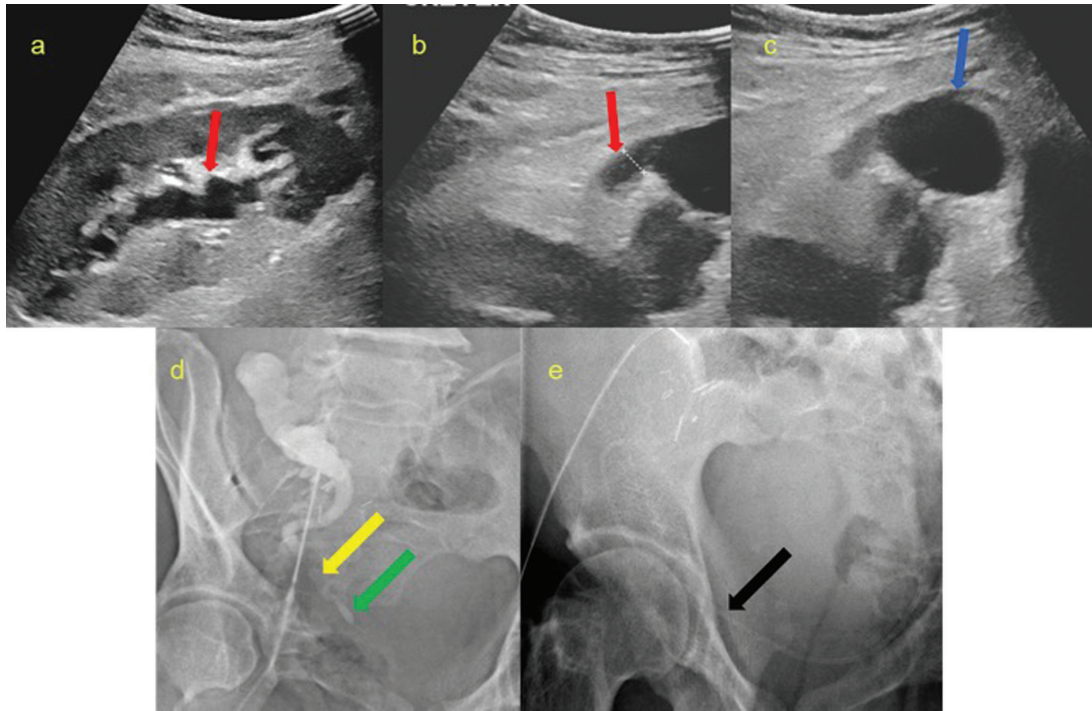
Images of 40-year-old male patient who underwent transplantation 3 weeks ago presented increased creatinine values. Ultrasound images (a–c) show mild hydronephrosis (*red arrow*). An anechoic collection (*blue arrow*) was noted at midureter level with compression over the ureter causing upstream hydronephrosis. Percutaneous nephrostogram (d) shows similar findings with narrowing at midureter level (*yellow arrow*) and normal sized distal ureter (*green arrow*). Fluoroscopic image (e) shows DJ stent (*black arrow*) across the compressed portion of the ureter, and the collection causing compression was aspirated. The patient creatinine level was improved. The collection turned out to be lymphocele. DJ, double J.
